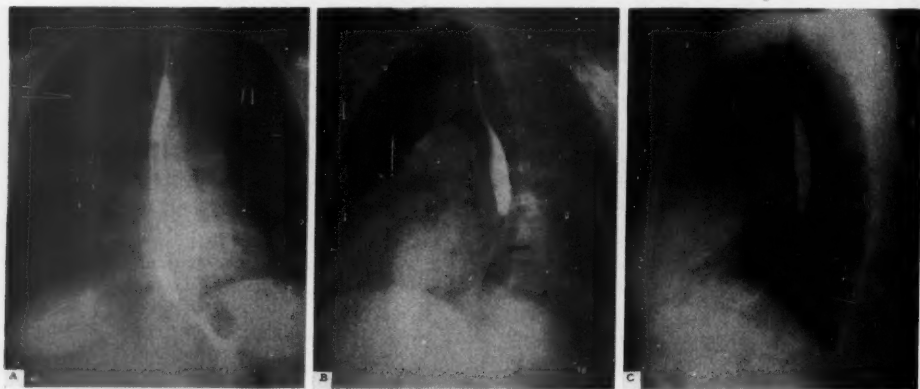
A. Posteroanterior roentgenogram of chest in a 43-year-old female with mitral stenosis. Note marked enlargement of the pulmonary artery. B. Right anterior oblique view in the same patient. C. Lateral view in same patient. Note enlargement of left atrium.
